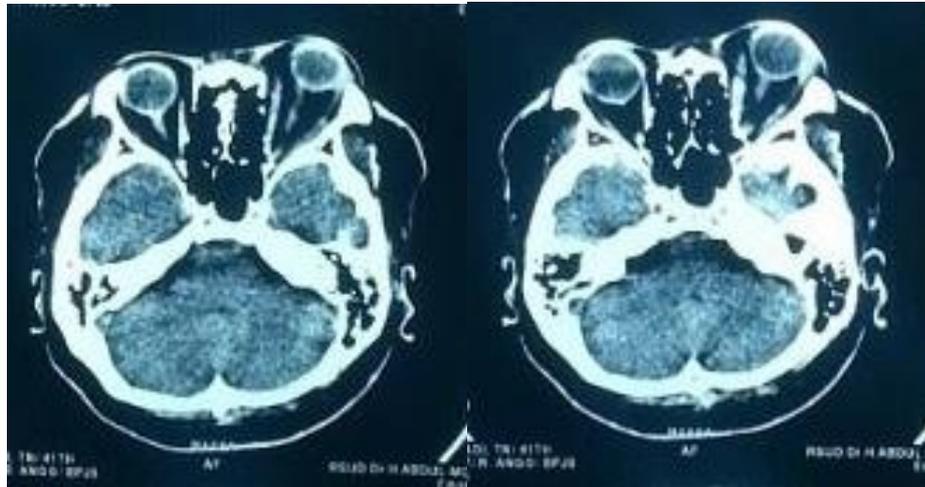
Orbital-head CT scan showed proptosis and enlarged of all the extraocular muscle of the left eye
